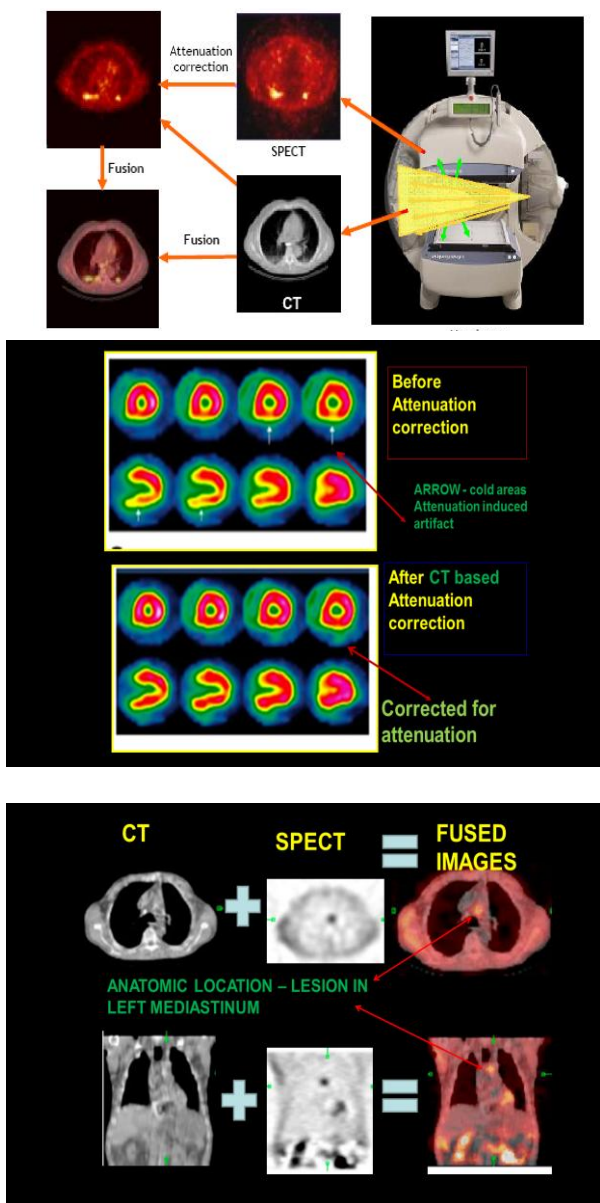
Implementation of SPECT camera
